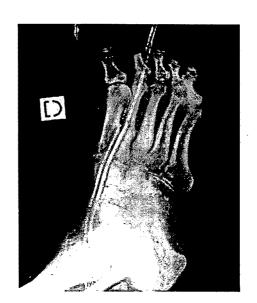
Case 2. Plain radiographs: severe diffuse demineralization of the entire right foot with soft tissue thicken 1 g. Bone scan: marked diffuse hyperactivity of the foot and ankle at all three phases, from the early vascular phase to the late bone phase.
